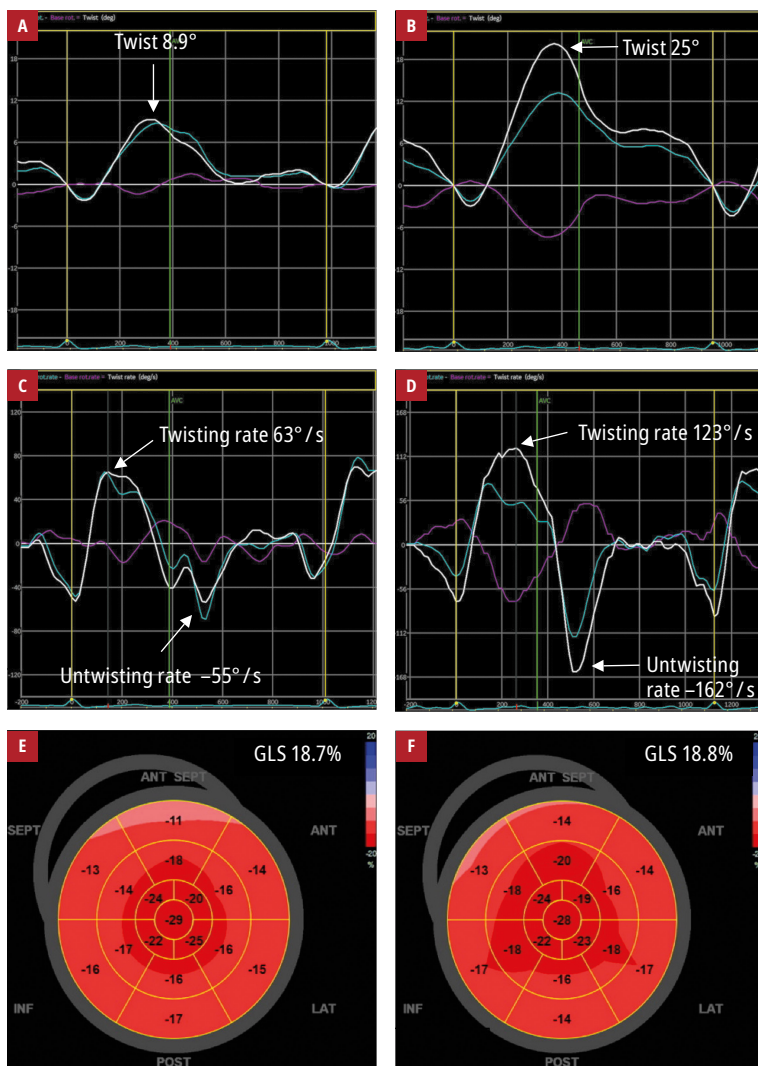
Two-dimensional speckle tracking echocardiography of a 42-year-old man with early diagnosed HH before (A, C, E) and after 6 months (B, D, F) of venesections. Twist (A and B), left ventricular twisting rate, and left ventricular untwisting rate (C and D) increased significantly; there were no changes in global longitudinal strain which was at a lower level of normal (E and F).
